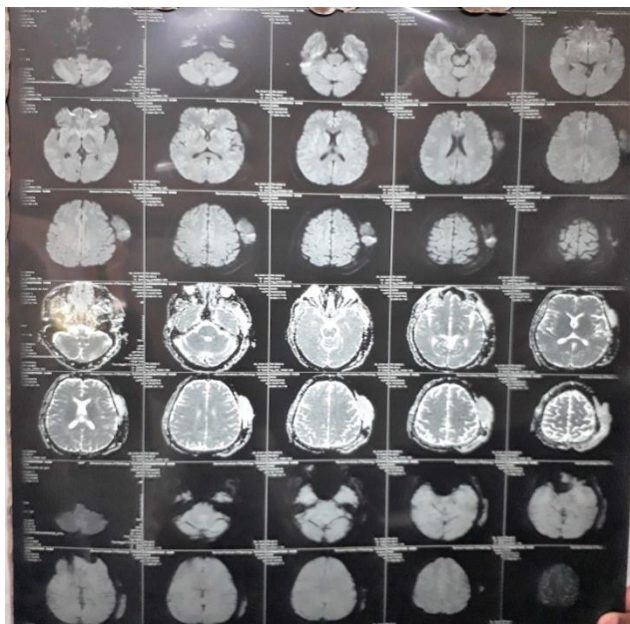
MRI Brain shows iso to hypointense mass lesion in left temporo-parietal region
